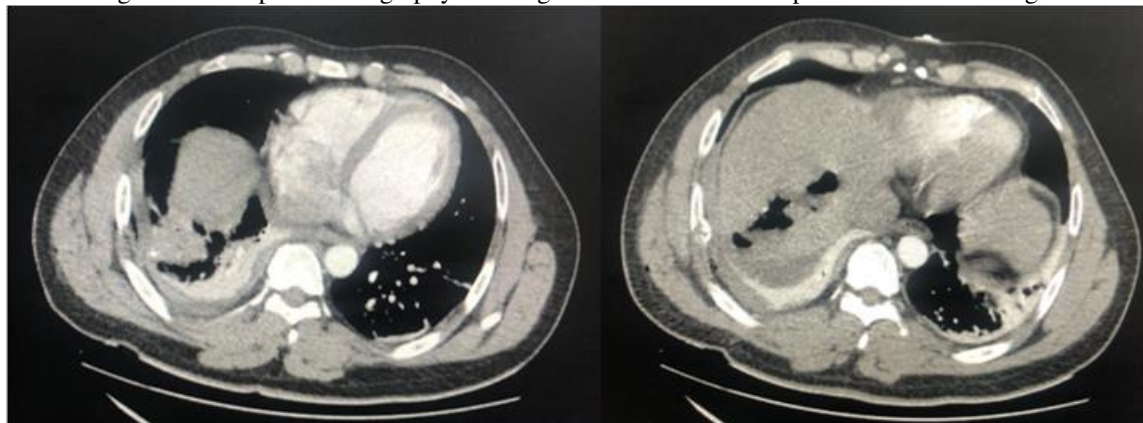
Computed tomography showing projectile entry and housing in hepatic segment II
